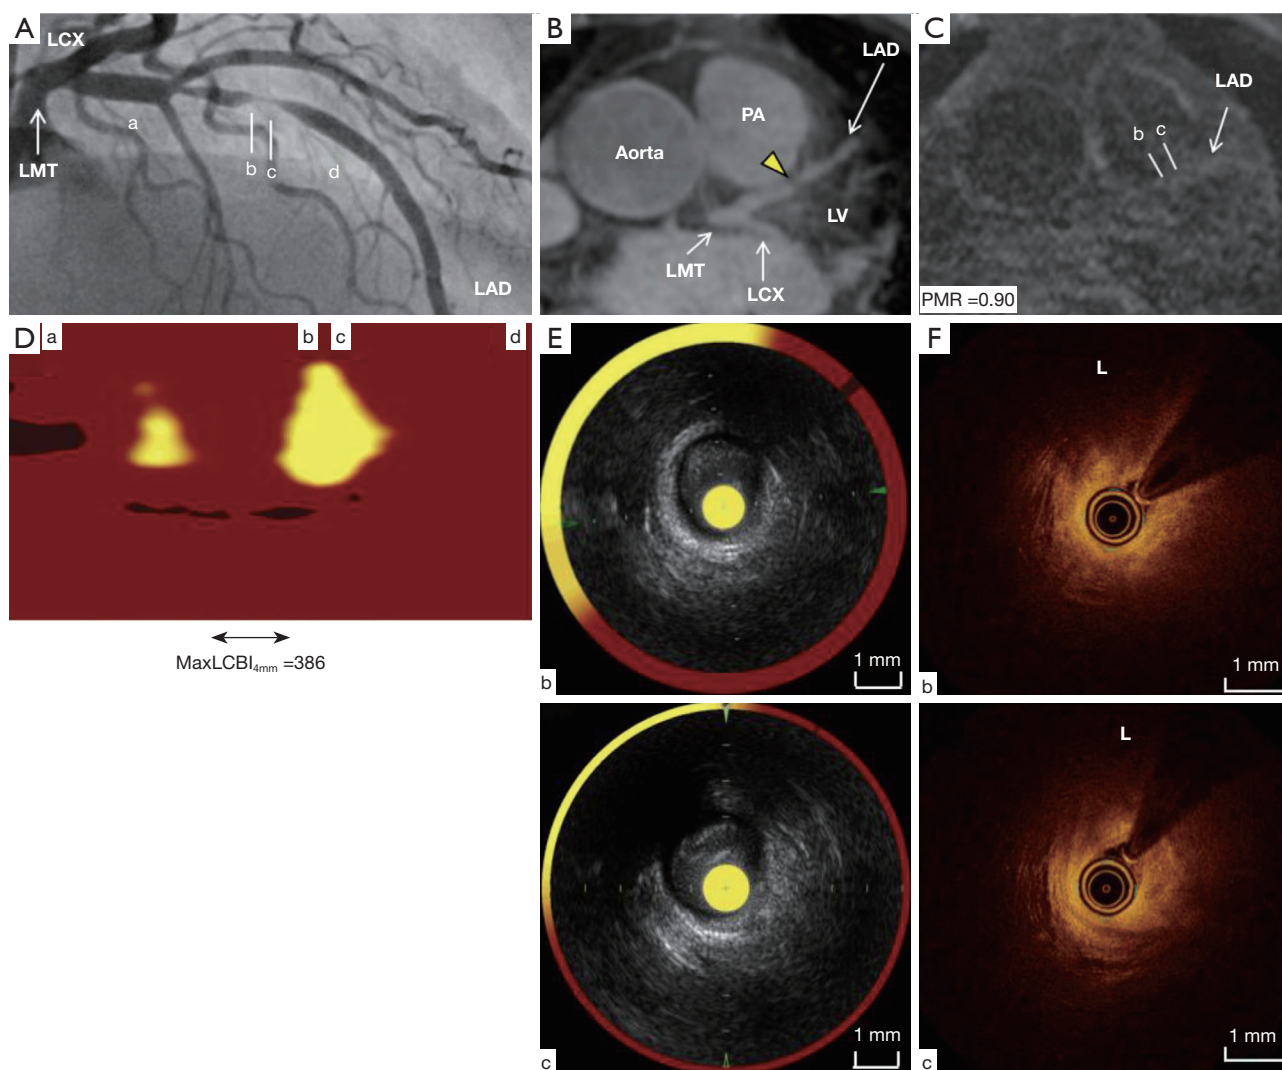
Imaging of culprit lesion in case 3. (A) Coronary angiography: there was a severe stenosis in the middle segment of LAD artery (b and c). a-d correspond to those in (C-F). (B,C) Non-contrast T1WI: MRA visualized the corresponding lesion in LAD artery (B, yellow arrowhead), where any high-intensity signal was not observed on non-contrast T1WI (C, $PMR=0.90$). (D,E) NIRS/IVUS imaging: $maxLCBI_{4mm}$ at this lesion was 386. IVUS showed the presence of low-echoic plaque but not ultrasonic attenuation (b and c). (F) OCT imaging: OCT demonstrated the presence of lipid plaque (L). However, the arc of lipid plaque was smaller (b and c) compared to those in other two cases. LCX, left circumflex artery; LMT, left main trunk; LAD, left anterior descending; PA, pulmonary artery; LV, left ventricular; PMR, plaque-to-myocardial signal intensity ratio; $maxLCBI_{4mm}$, maximum 4-mm lipid core burden index; T1WI, T1-weighted imaging; MRA, magnetic resonance angiography; NIRS, near-infrared spectroscopy; IVUS, intravascular ultrasound; OCT, optical coherence tomography.
